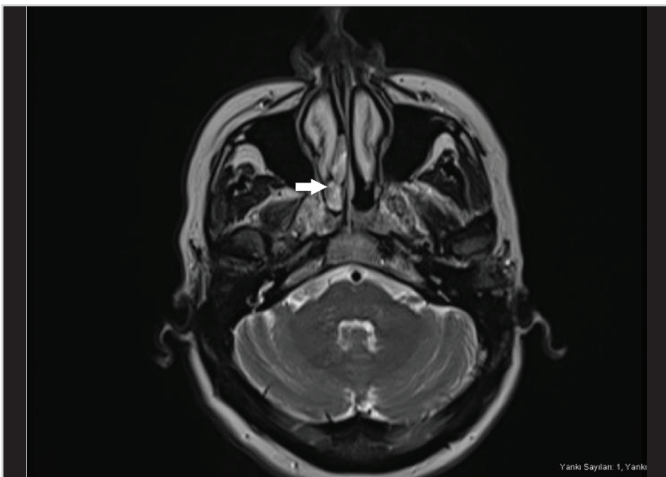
b. A hyperintense lesion was observed in the right nasal cavity on T2-weighted sequences of MRI
